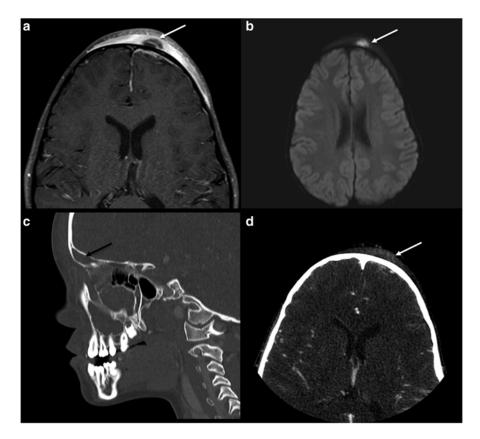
Pott's Puffy Tumor. (a) MRI post axial T1 (b) MRI axial DWI (c) contrast CT sagittal (d) contrast CT axial. There is peripherally enhancing subperiosteal abscess in the left anterior frontal area with marked adjacent scalp edema. There is associated dural thickening and enhancement in the left frontal convexity and interhemispheric fissure. *White arrow* shows restricted diffusion in the abscess. *Black arrow* shows acute frontal sinusitis with complete fluid opacification
